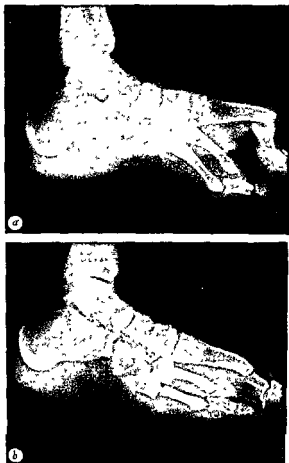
Preoperative lateral roentgenograms; b, postoperative view of the same foot. The rudimentary joints appearing in these roentgenograms do not show the extent of fusion found at operation.
